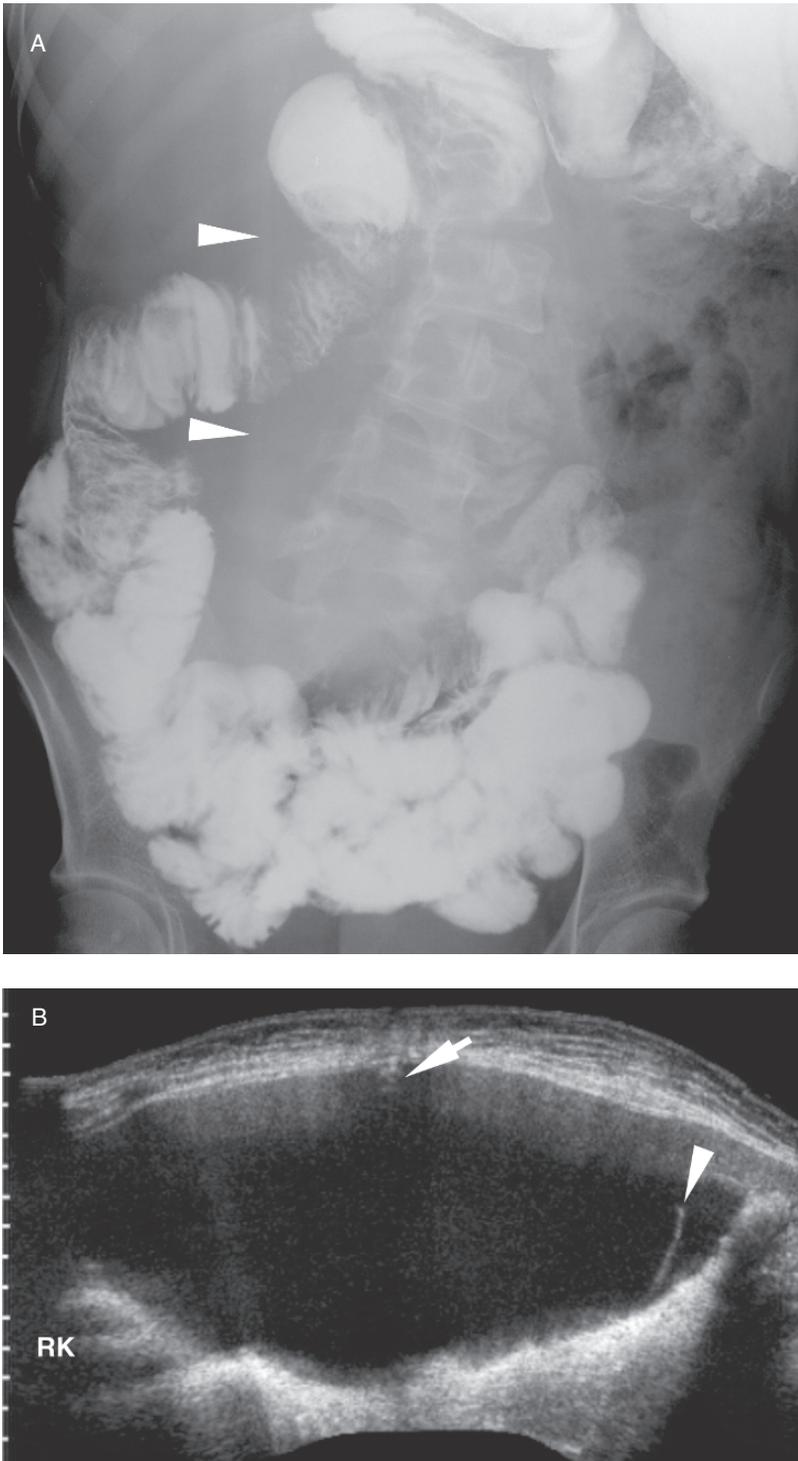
CSF pseudocyst. (A) Barium study in a patient with spinal dysraphism and abdominal distension and a VPS (arrowheads) shows a mass displacing loops of small bowel. (B) Longitudinal extended field of view sonogram shows a 22-cm-long pseudocyst associated with the VPS (arrow). There is a single septations within the cyst (arrowhead). RK = right kidney.
